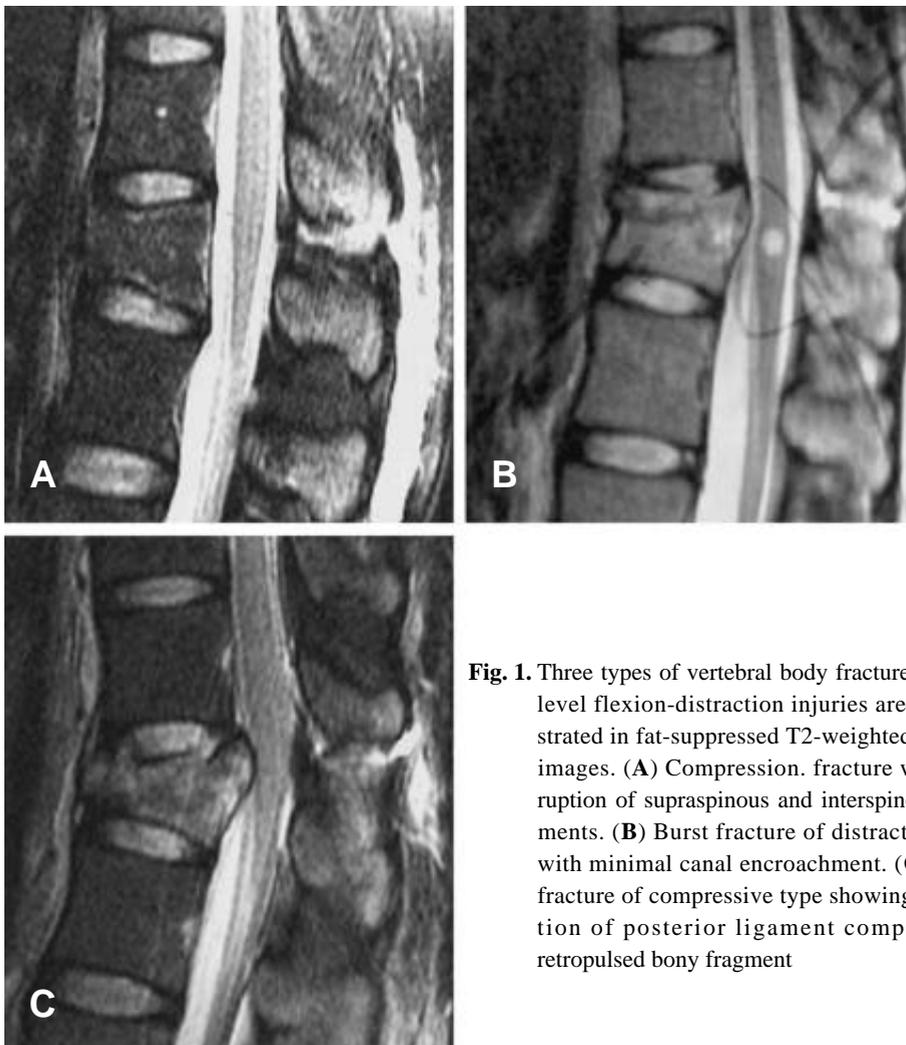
Three types of vertebral body fractures of two level flexion-distraction injuries are demonstrated in fat-suppressed T2-weighted sagittal images. (A) Compression fracture with disruption of supraspinous and interspinous ligaments. (B) Burst fracture of distractive type with minimal canal encroachment. (C) Burst fracture of compressive type showing disruption of posterior ligament complex and retropulsed bony fragment
